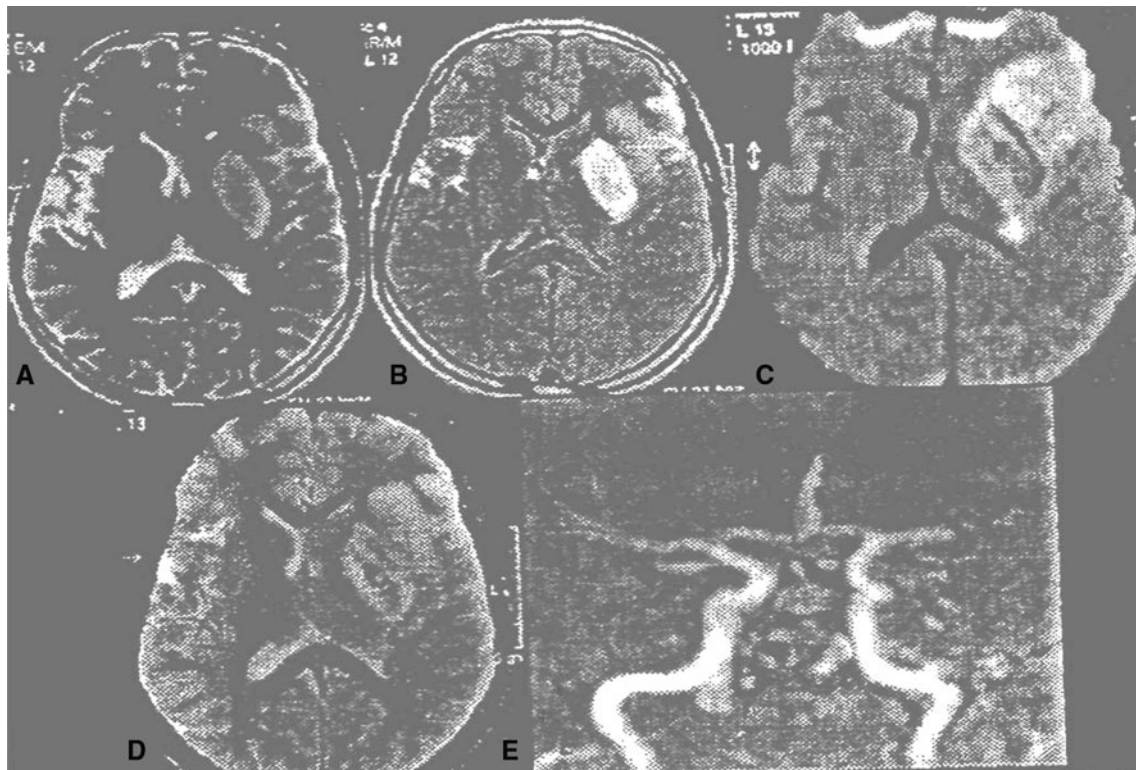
FLAIR (a), T2WI (b), DWI (c), T2WIGR (d) and MRA (e) images of a 20-year-old female with SLE of 1-year duration. She developed acute right-sided hemiplegia (CVS). Her MRI (a, b) showed left hyperintense cortical and subcortical parietal lesion
